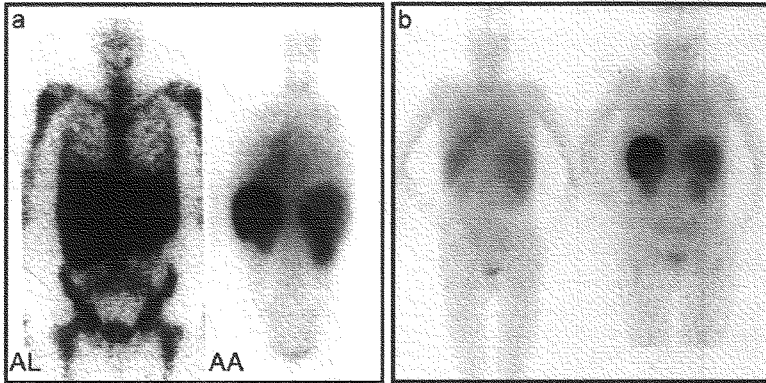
Whole-body scintigraphy with ^{123}I -labeled serum amyloid P component in systemic amyloidosis. (a) *Left*: Anterior view of a typical patient with AL amyloidosis showing massive liver and spleen amyloid and the pathognomonic deposits throughout the bone marrow that are not seen in any other type of amyloidosis. *Right*: Posterior view of a typical patient with AA amyloidosis showing amyloid in the spleen, kidneys, and adrenal. The left adrenal is obscured by the overlying spleen, but the right is clearly visible above the kidney. (b) Posterior scans taken a year apart in a patient with longstanding rheumatoid arthritis who suddenly developed AA amyloidosis. The earlier scan (*left*) is normal; the later one (*right*) shows heavy splenic and significant renal amyloidosis.
